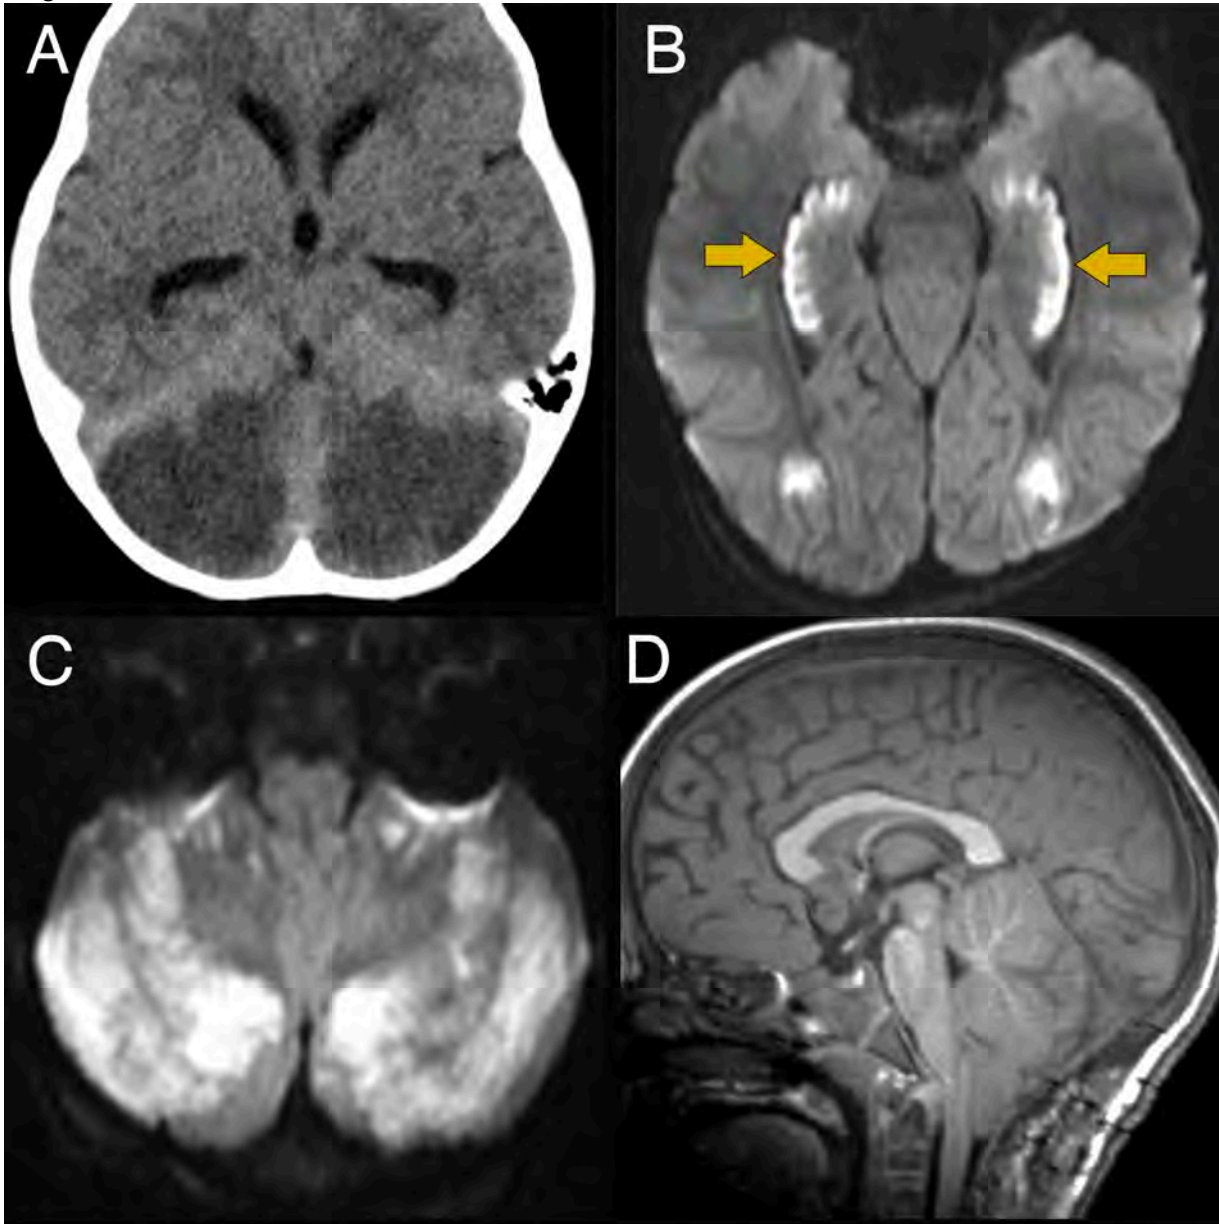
Pediatric Opioid Use-Associated Neurotoxicity with Cerebellar Edema (POUNCE) in a 2-year-old unresponsive girl with urine toxicology positive for opioids. Axial noncontrast CT (A) shows marked cerebellar edema bilaterally, along with mild ventriculomegaly. On MRI, DWI (B and C) shows symmetric restricted diffusion in the hippocampi with a curvilinear appearance (arrows), as well as in the suboccipital white matter. There is also prominent restricted diffusion in the cerebellum (C). Sagittal noncontrast T1 demonstrates fulminant cerebellar edema with persistent mass effect in the posterior fossa after suboccipital decompression (D).
